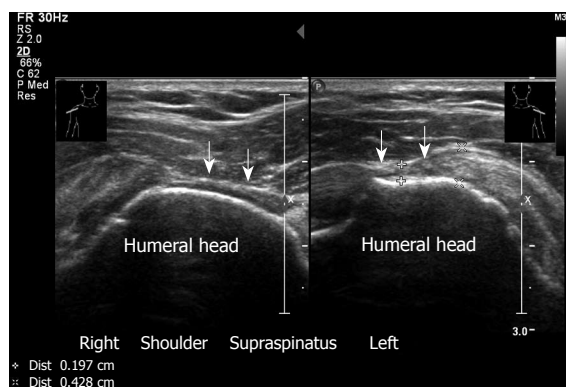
Partial thickness tear of supraspinatus. Right and left shoulder. Note the narrowing of the tendon. Transverse sonogram. A 70-year old male who presents with bilateral shoulder pain and has a painful arc at clinical examination.
